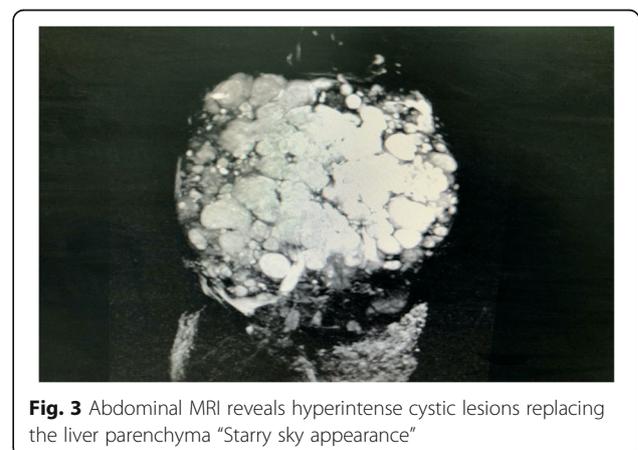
Abdominal MRI reveals hyperintense cystic lesions replacing the liver parenchyma "Starry sky appearance"
